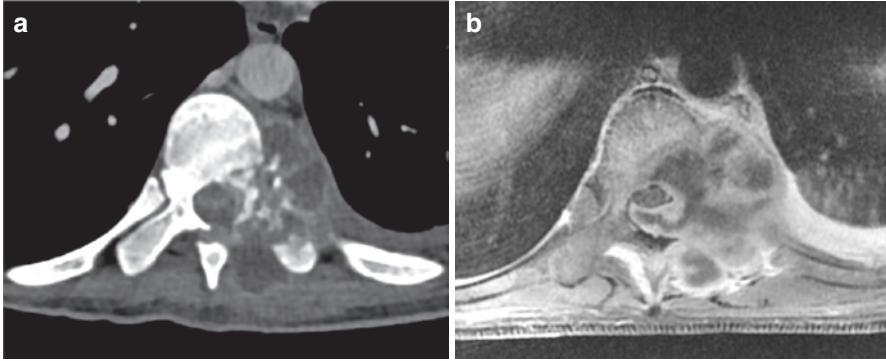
Axial CT (a) sections soft tissue window showing lytic lesions involving the left pedicle, adjacent lamina and posterior body of dorsal vertebra. On axial T1 post-contrast study (b): associated soft tissue extending into the spinal canal is also seen—Neural arch tuberculosis
